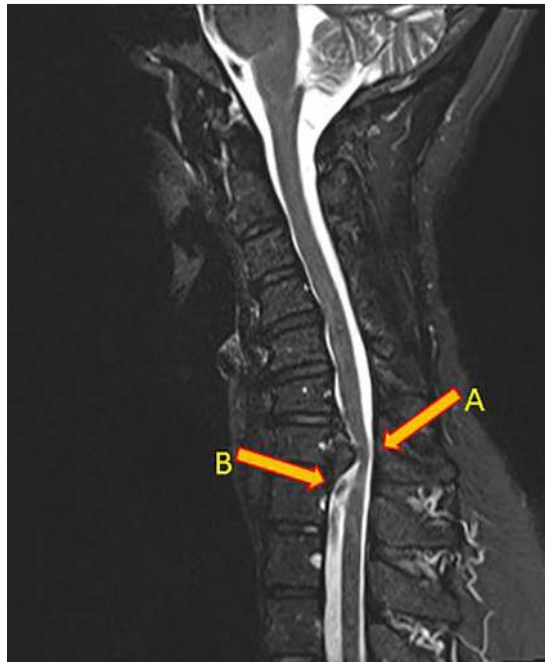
Short T1 inversion recovery (STIR) magnetic resonance image showing an osteochondroma causing spinal cord compression (A) in a patient with multiple hereditary exostoses. The patient presented with myelopathy and mild spinal cord signal changes. Arrow B indicates decreased signal within the cerebrospinal fluid representing a flow related artefact. Courtesy of Brandon Childers, Department of Radiology, Johns Hopkins
